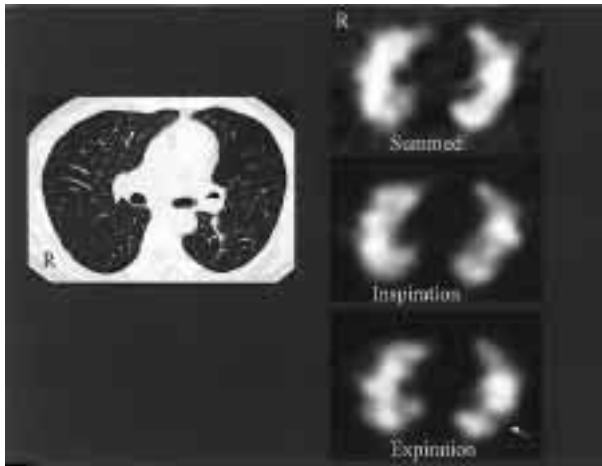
Respiratory-gated ^{99m}Tc -Technegas SPECT study in a 41-year-old patient with diffuse panbronchiolitis. The chest CT image (*left*) at the lung level corresponding to the SPECT plane shows only focal tiny opacities along the peripheral bronchi. Although the conventional summed SPECT image shows heterogeneously-decreased Technegas distribution in both lungs, the ventilation heterogeneity and some of focal ventilation defects are more clearly seen on the matched inspiration and/or expiration phase SPECT images. A linear ventilation defect corresponding to the left major fissure is seen (*arrow*).
